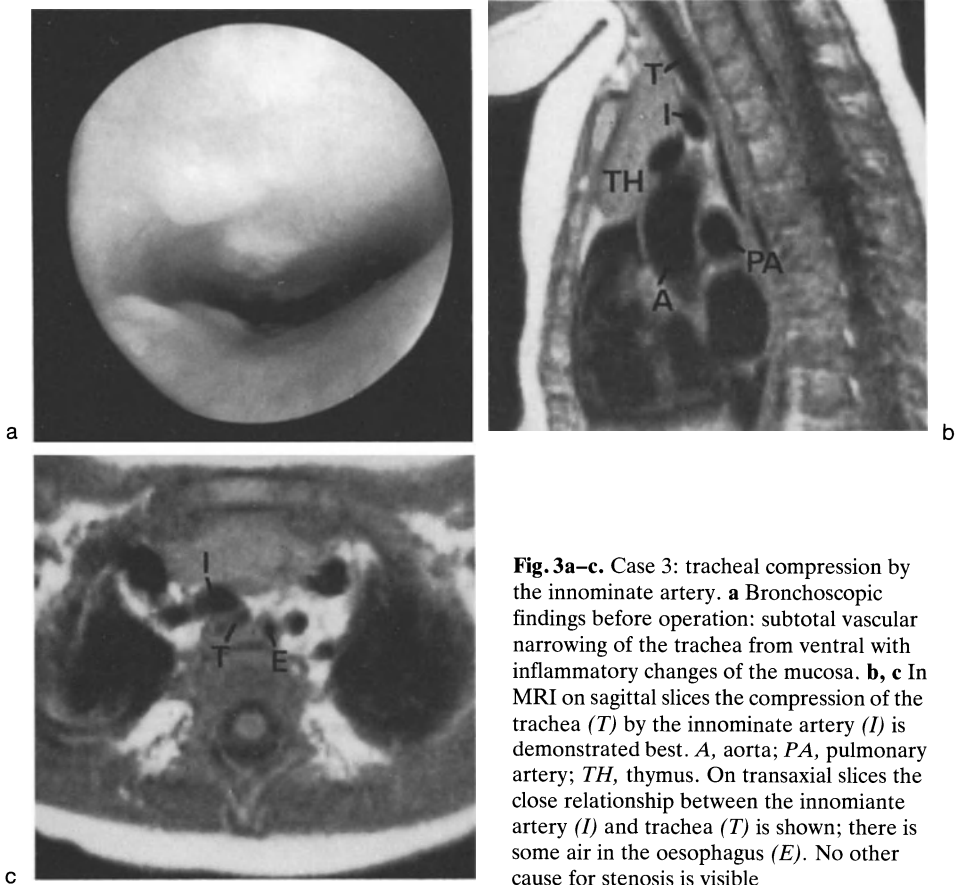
Case 3: tracheal compression by the innominate artery. a Bronchoscopic findings before operation: subtotal vascular narrowing of the trachea from ventral with inflammatory changes of the mucosa. b, c In MRI on sagittal slices the compression of the trachea (*T*) by the innominate artery (*I*) is demonstrated best. *A*, aorta; *PA*, pulmonary artery; *TH*, thymus. On transaxial slices the close relationship between the innominate artery (*I*) and trachea (*T*) is shown; there is some air in the oesophagus (*E*). No other cause for stenosis is visible
